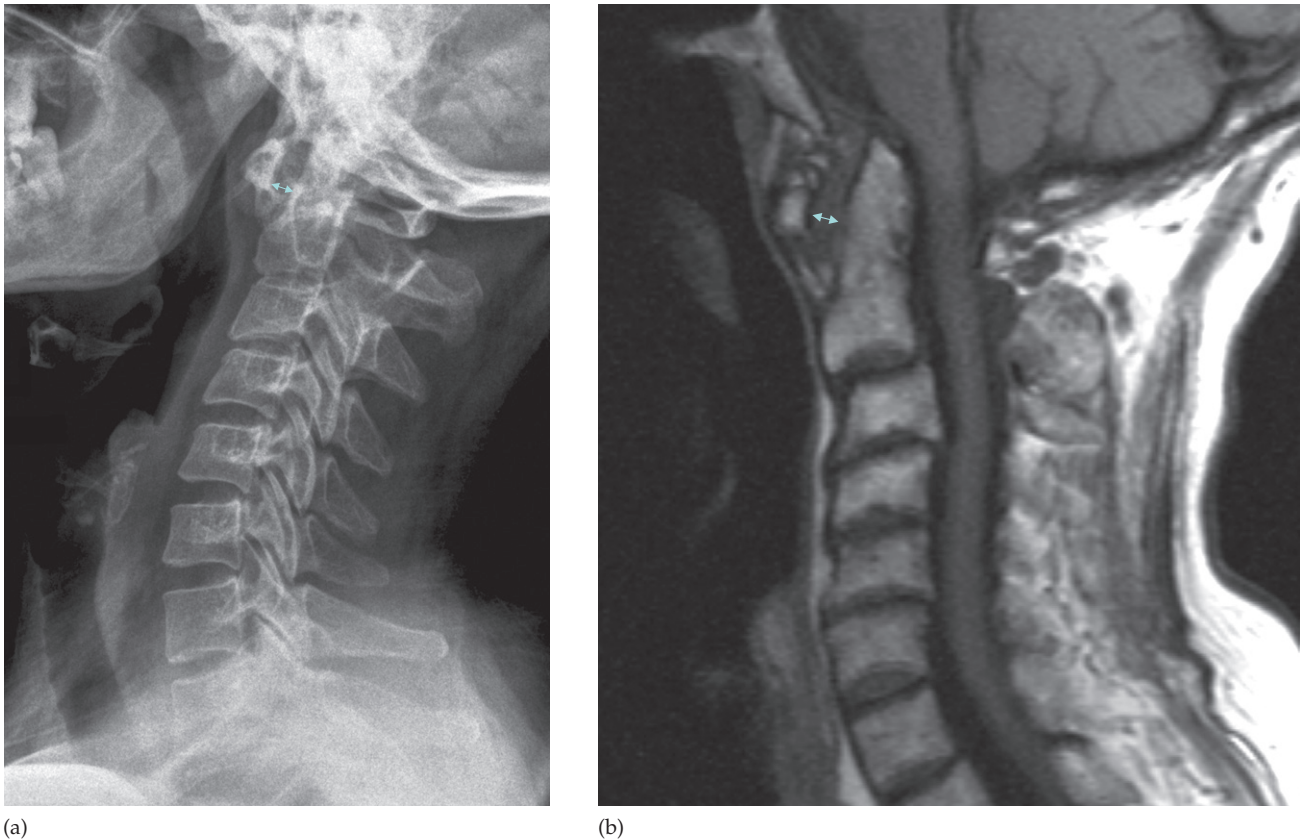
Atlanto-axial subluxation. (a) Plain film taken with the neck flexed showing widening of the space between the dens of C2 and the anterior aspect of C1 (double arrow) in a patient with rheumatoid arthritis. (b) T1-weighted MRI showing widening of the atlanto-axial space in the same patient even when supine in the scanner.
